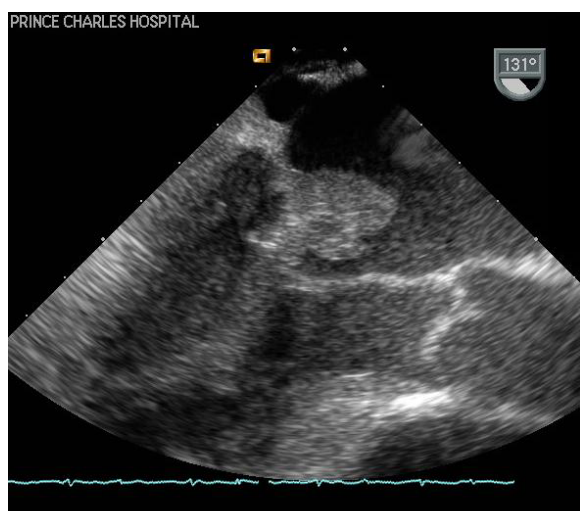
A post collapse transoesophageal echocardiograph showing the fimbriated mass.
